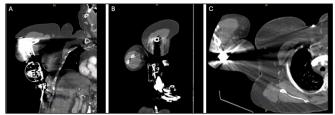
Non-diagnostic upper extremity CT angiography displaying difficulty with positioning and significant beam hardening artifacts from the handlebar. A) Coronal plane B) Sagittal plane C) Axial plane.
